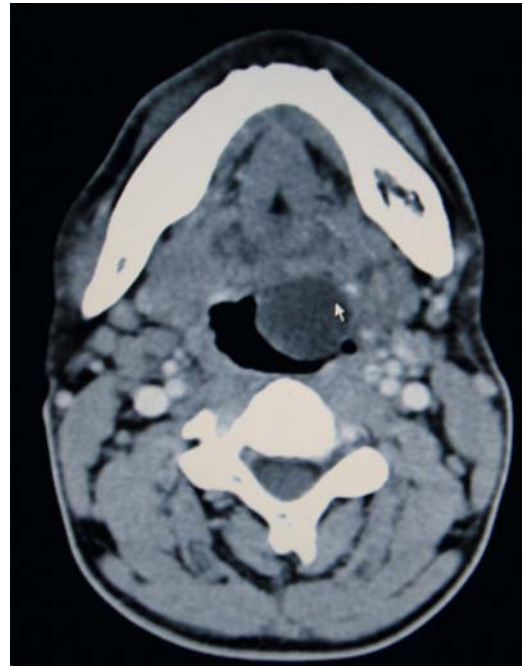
CT scan-axial view of the neck (contrast) showing a cystic lesion at the root of tongue
